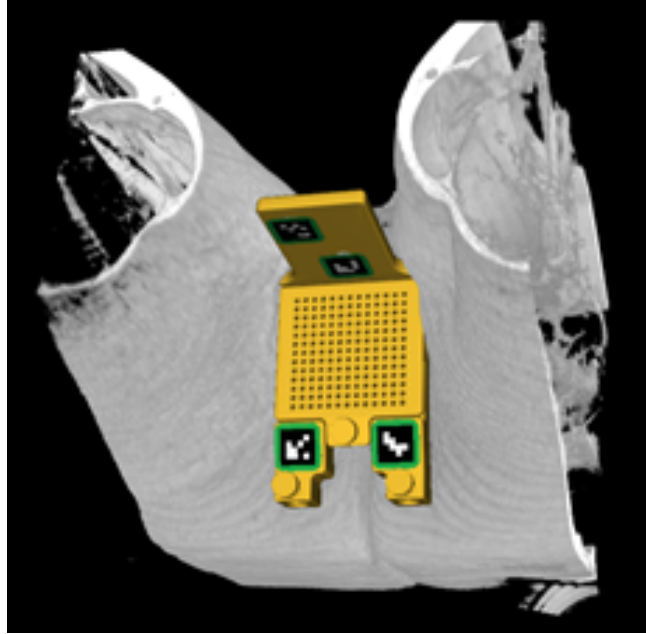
Automatically detected grid within MRI.
